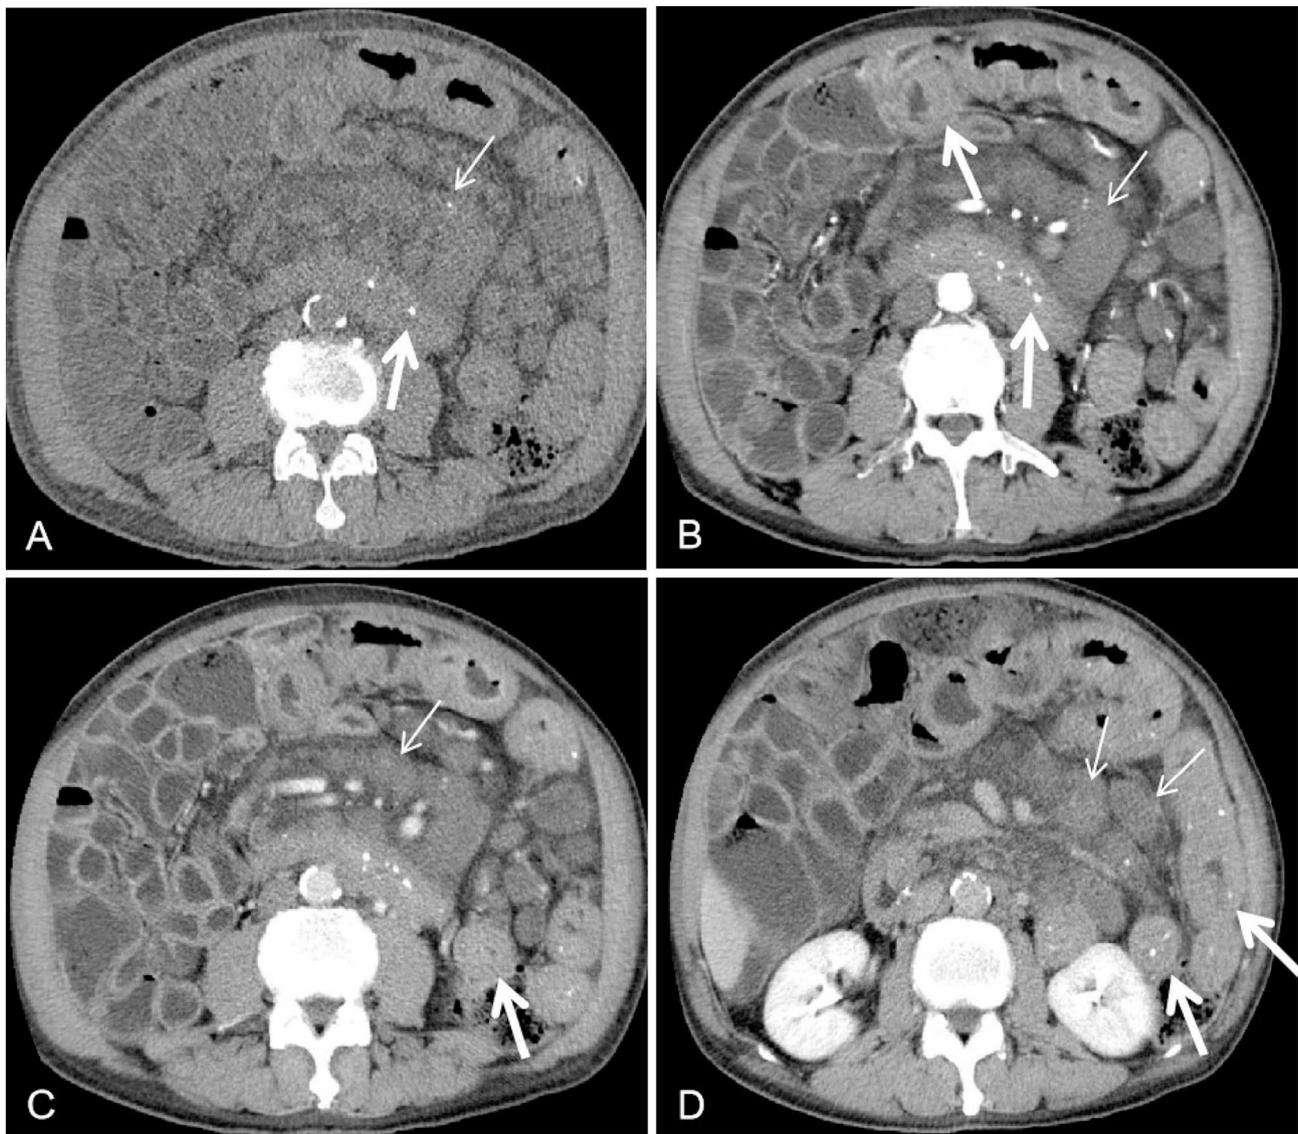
A patient with non-hematogenous disseminated ATBL combined with small bowel tuberculosis had a 6-month history of abdominal distension. Axial CT plain scan images showed multiple enlarged lymph nodes in the mesentery, some of which were calcified (thin white arrow), and the wall of the small intestine was thickened and calcified (thick white arrow) (A). Axial contrast-enhanced images showed that multiple enlarged mesenteric lymph nodes had homogeneous low enhancement (thin white arrows), and the thickened small intestinal wall had homogeneous enhancement (thick white arrows) (B, C, D)
